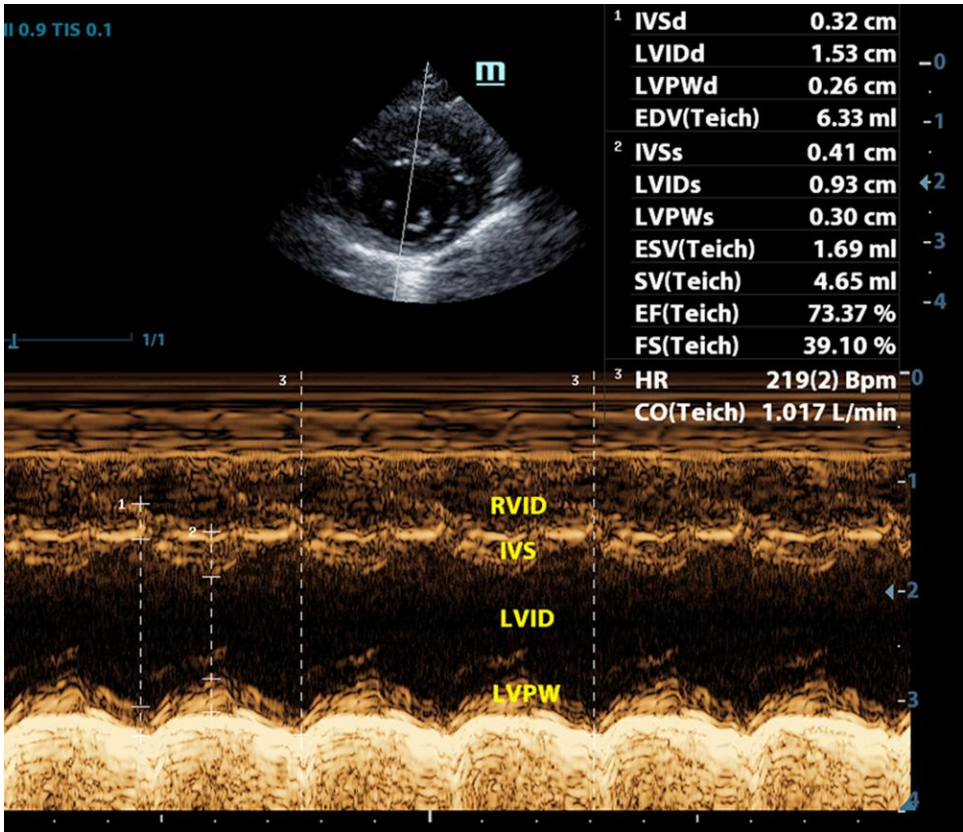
From the right parasternal short axis at the level of papillary muscles, measurement of echocardiographic M-Mode parameters of the left ventricle. RVID: right ventricle internal diameter, IVS: interventricular septum, LVID: left ventricle internal diameter, LVPW: left ventricle posterior wall, EF: ejection fraction, FS: fractional shortening, HR: heart rate, CO: cardiac output.
